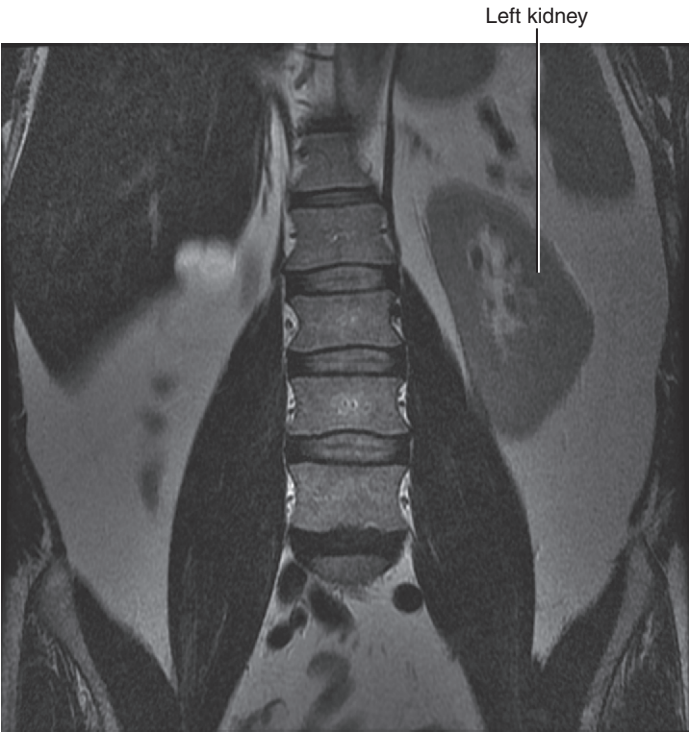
Crossed fused renal ectopia, demonstrated on sequential T2-weighted magnetic resonance images that run from posterior to anterior in the coronal plane (see Figs. 12-22 to 12-24). This image demonstrates an empty right renal fossa. (Image courtesy of Vikram Dogra, MD.)
